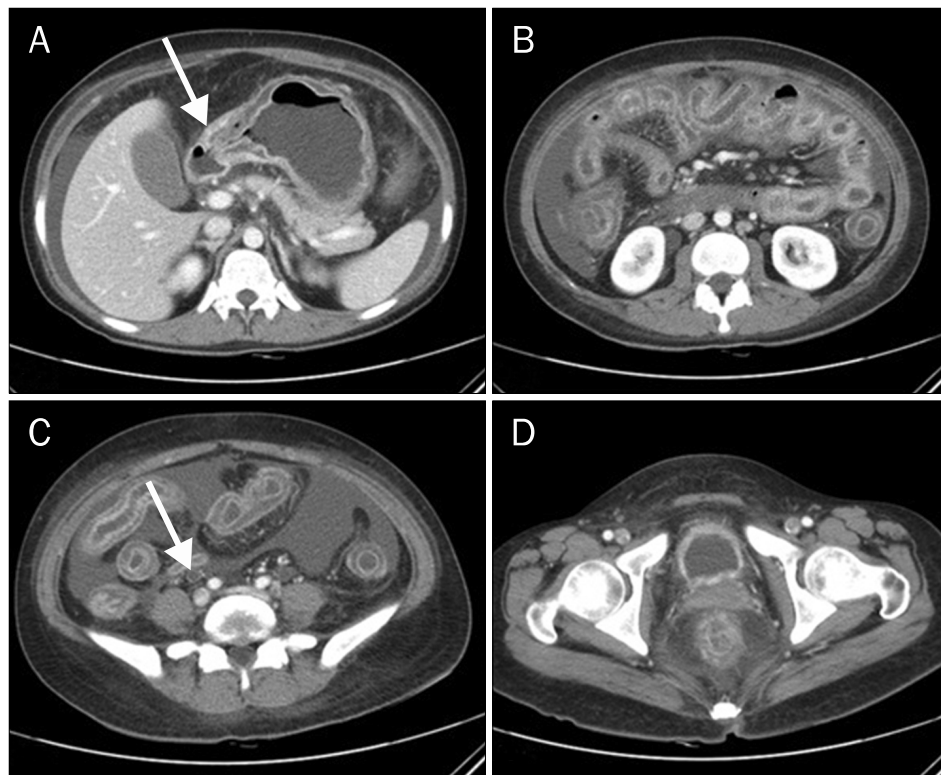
CT of the patient shows moderate amount of ascites and diffuse hypodense submucosal thickening involving the stomach lower body (A), entire small bowel (B), colon (C), appendix and rectum (D). Submucosal wall thickening of stomach lower body (A, arrow). Focal enhancement of right ureter (C, arrow), suspicious systemic lupus erythematosus involvement.
